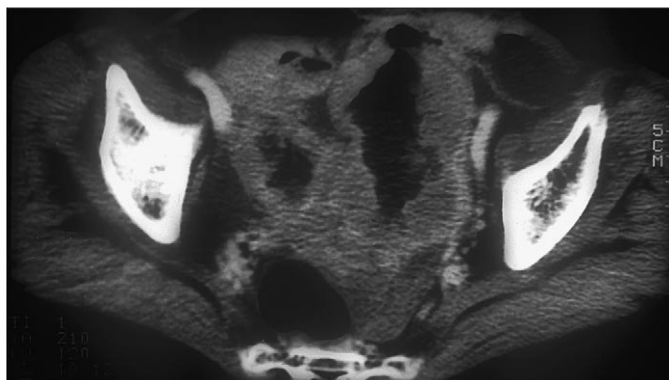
A 70-year-old woman was admitted with lower abdominal pain. An 8-cm mass was palpable in the left lower quadrant of the abdomen. Abdominopelvic computed tomography showed irregular thickening of the small bowel on the left side of the abdominal cavity.
